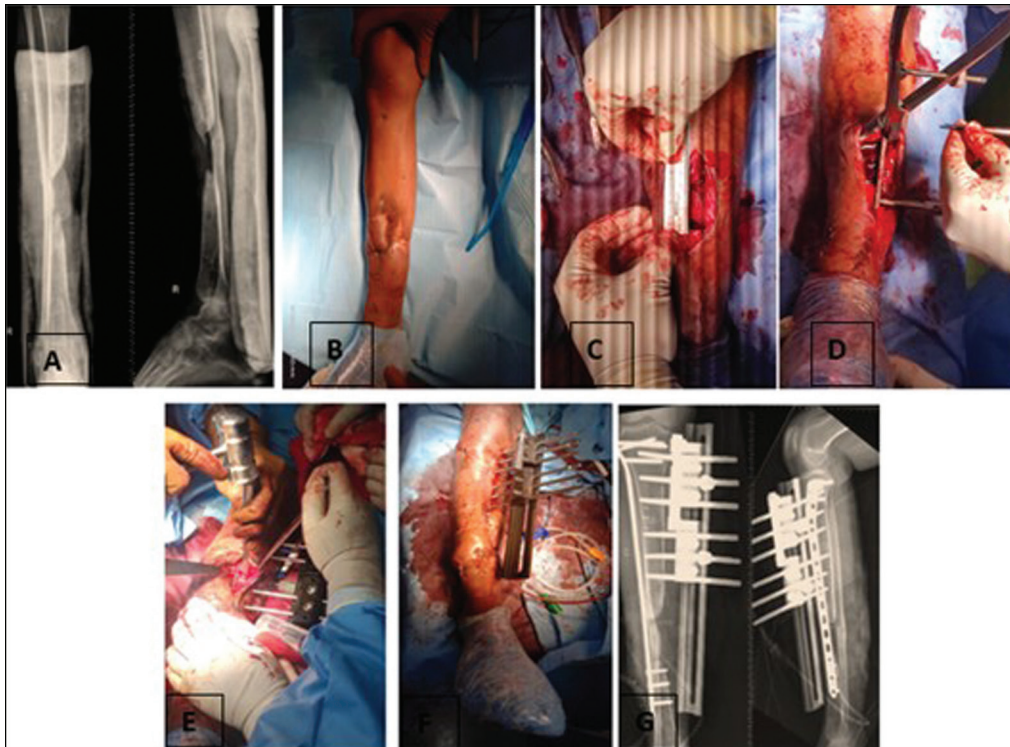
Case example showing. (A) Preop radiograph showing segmental tibial defect in lower third of tibia. (B) Intraop clinical image showing healed flap site with no active discharge. (C) Intraop debridement with freshening of bony edges and measurement of bone gap (4.5cm in this case). (D) Insertion of lateral tibial plate with minimal invasive technique. (E) Corticotomy between two LRS clamps after LRS application from medial side. (F) Intraop image after completion of surgery. (G) Postop radiograph showing LRS and tibial plate in place
